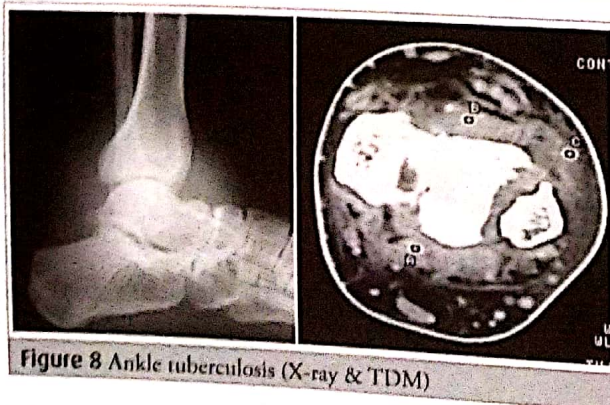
Ankle tuberculosis (X-ray & TDM)
